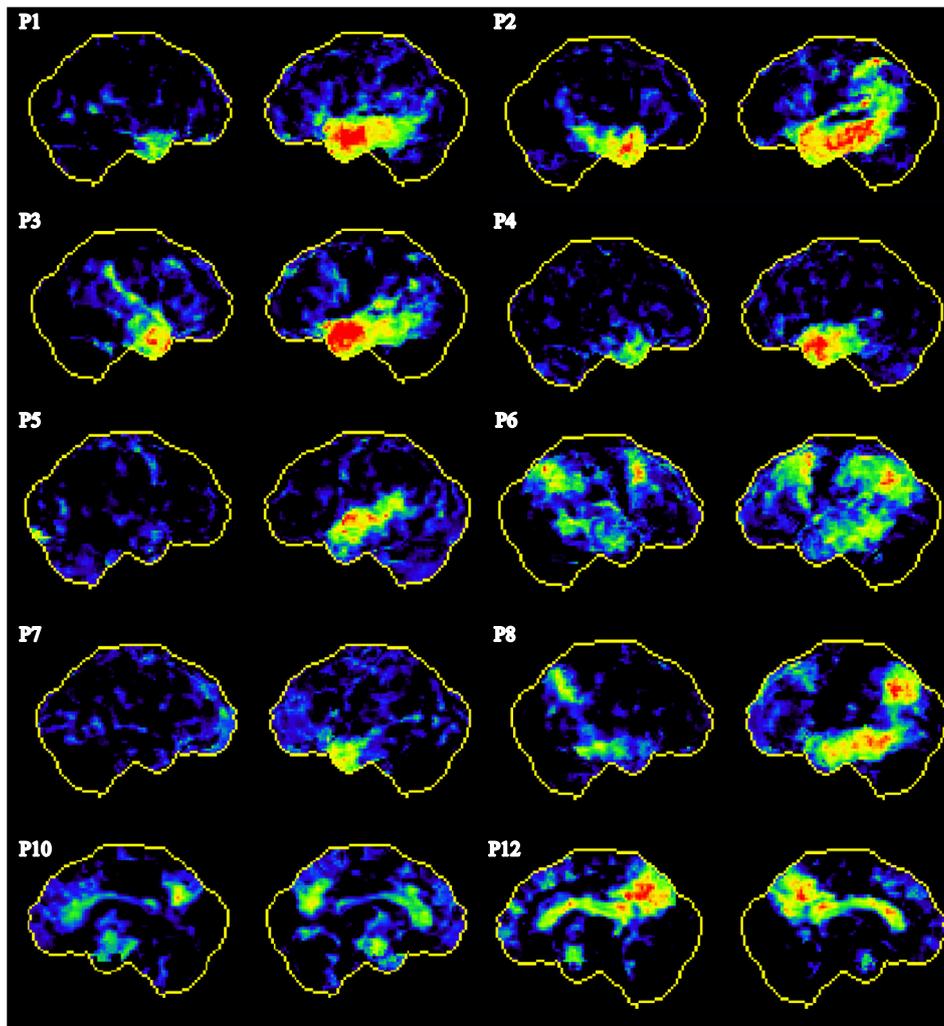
FDG-PET scans of participants diagnosed with svPPA (P1, P2, P3 and P4), lvPPA (P5, P6, P7 and P8), and AD (P10 and P12).
